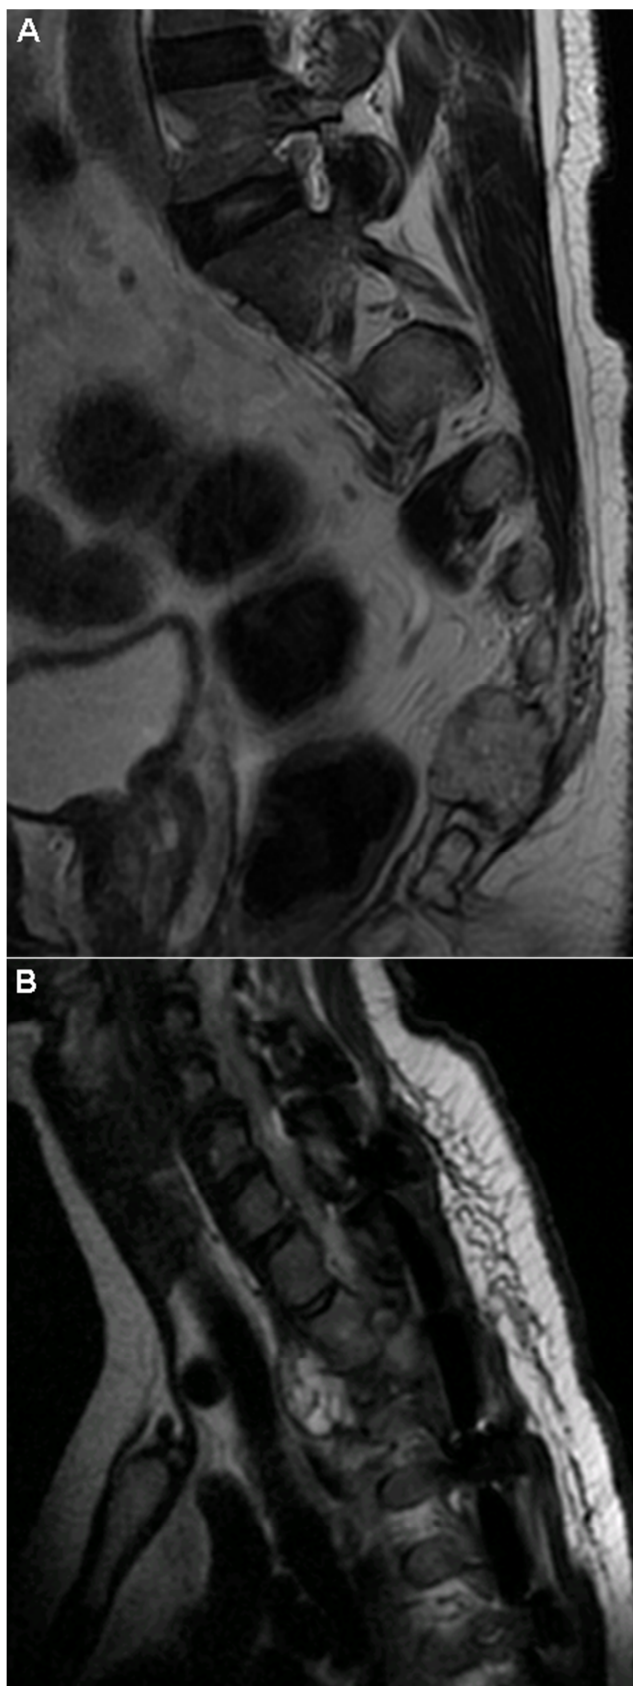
Sagittal T2-weighted magnetic resonance imaging of the sacrum shows osteolysis and destruction of the coccyx with anterior soft tissue mass. Biopsy showed epithelioid hemangioendothelioma of the coccyx. Figure B: Sagittal T1-weighted magnetic resonance imaging of the thoracic spine of a patient with recurrent epithelioid hemangioendothelioma of the T3 vertebra.
